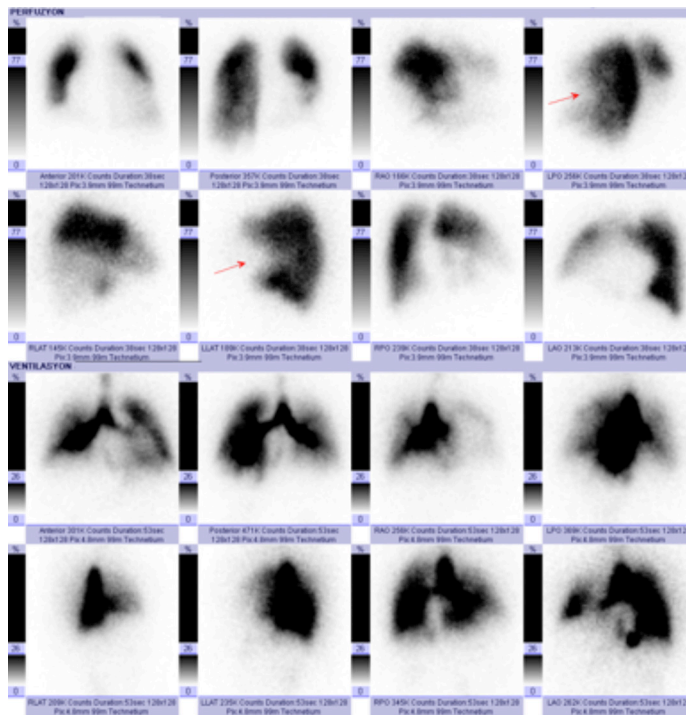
V/Q-scan of the study patient. A subsegmental perfusion defect was observed in the upper lobe superior lingual, inferior lingual and lower lobe superior segments of the left lung (red arrow). Ventilation scintigraphy showed ventilation in these areas (mis-match defect).
